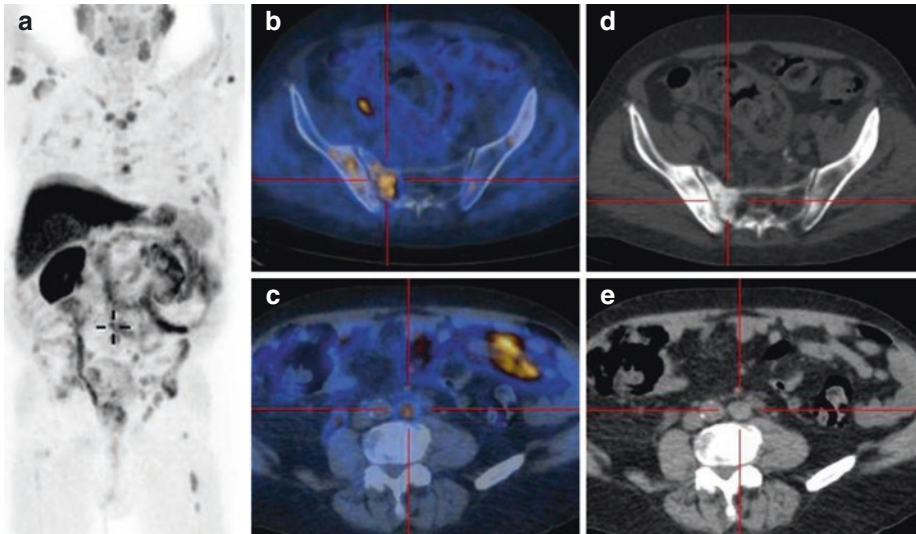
A patient examined by ^{18}F -FMC PET/CT for high PSA value (68 ng/mL), prior to undergone antiandrogenic therapy. PET maximum intensity projection (a) shows pathologic tracer uptake in multiple bone lesions.
